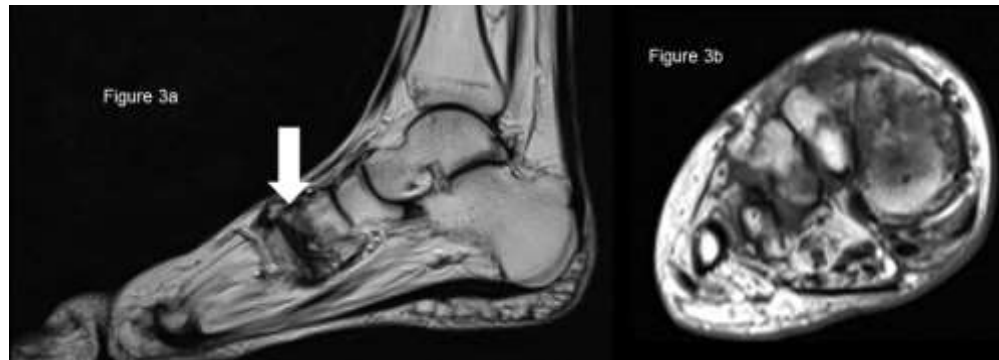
Left foot MRI T1 sagittal and axial views demonstrating a destructive arthropathy of the common tarsometatarsal joint resulting in pes planus (solid arrow). There is marrow edema and severe erosive changes in the midfoot consistent with a Charcot neuroarthropathic joint. There is also collapse of the second metatarsal head.”
